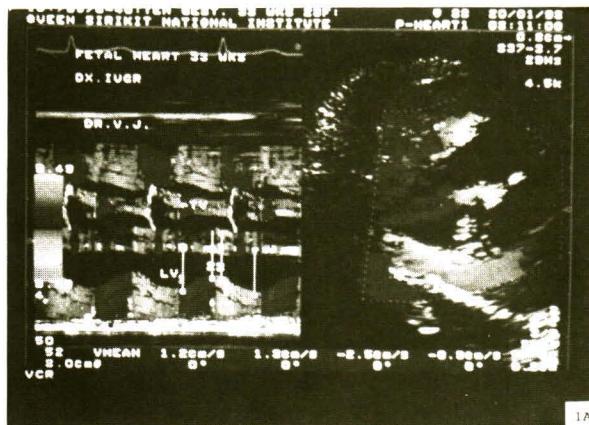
Tissue Doppler Imaging with the colour - coded M-mode of a normal fetal heart with a gestational age of 33 weeks : normal endomyocardial velocity during systole and diastole of the posterior wall of the left ventricle (A) and the anterior wall of the right ventricle (B). The interventricular septum was incorrectly colour-coded due to abnormal interventricular septal motion and fetal heart motion.
